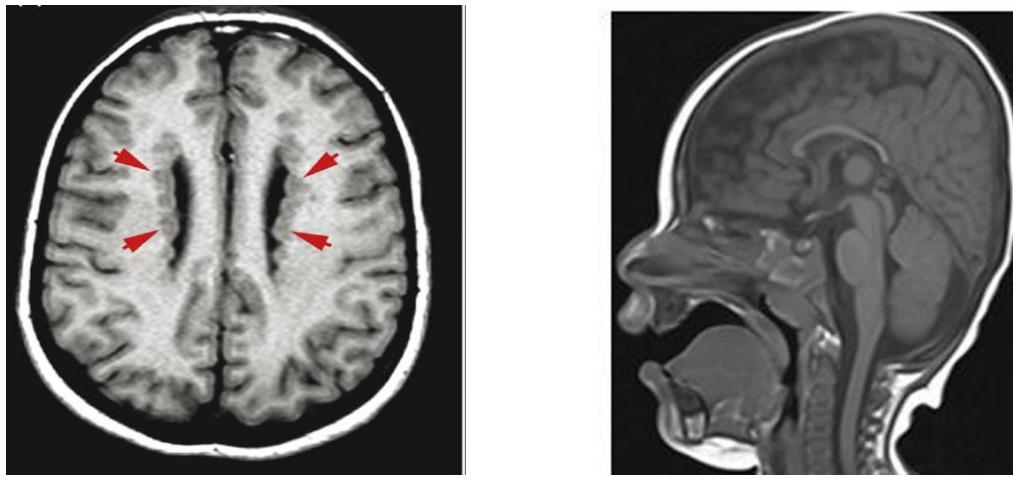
Brain MRI of patients with a homozygous *ARFGEF2* mutation show periventricular heterotopia with thin corpus callosum. Left: horizontal section-T2 weighted. Periventricular heterotopia seen in the lateral ventricles of patient ([Sarkisian M, 2008](#)) . Right: thin corpus callosum in a T1-weighted MRI sagittal section ([Banne E, 2013](#)).
